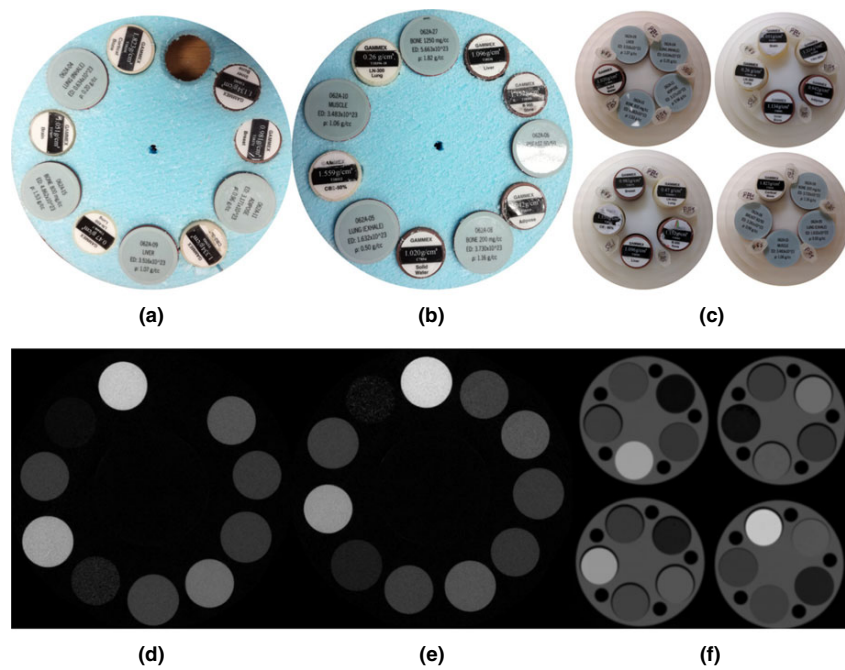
Synchrotron CT images (d,e) and dual-layer CT images (f) at 50 keV of the same inserts with different configurations shown in (a-c). Figure re-printed from [J19].
